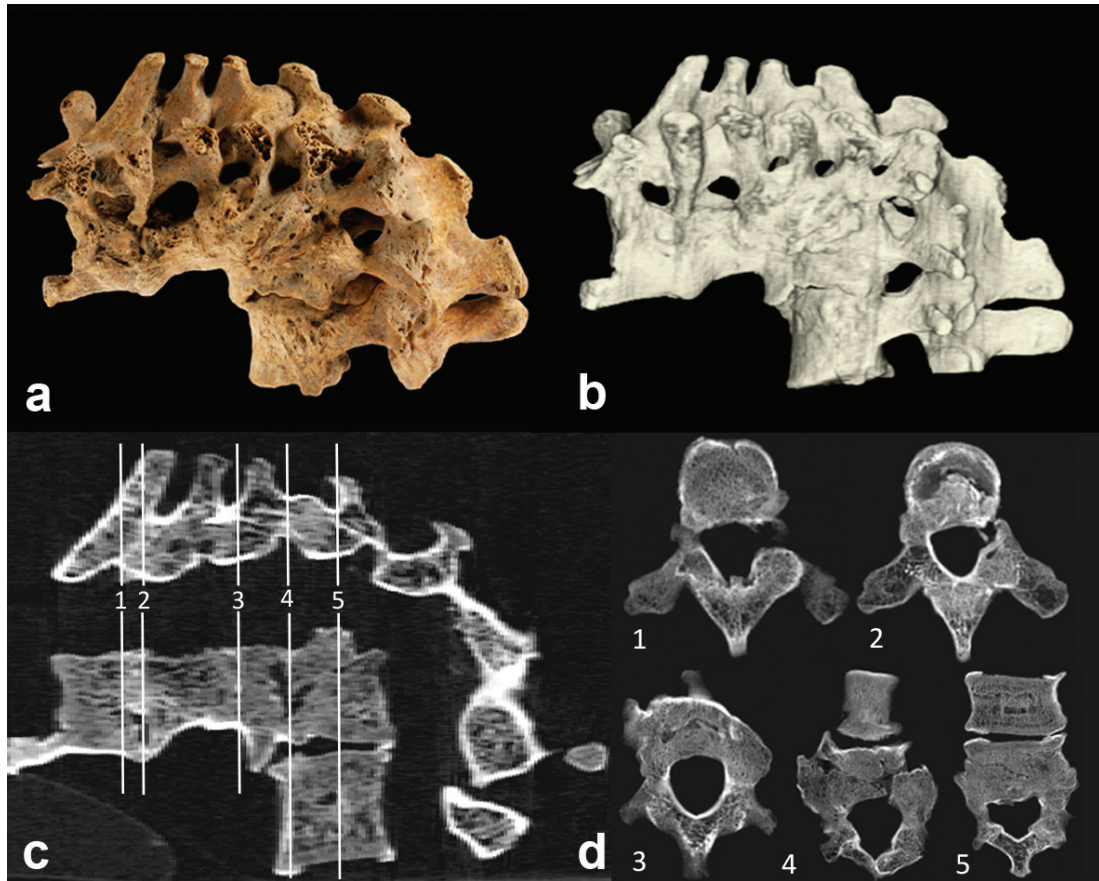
Advanced stage Pott's disease. Morphological picture, 3D reconstruction and CT images of the thoracolumbar spine remains from the Szeged-Vár cemetery (Grave 483). a: macromorphological picture of the spine. b: CT-based 3D (VRT) reconstruction of the spine remains. c-d: lateral view (MPR) CT images of the thoracolumbar spine and separated images of the affected vertebrae.
